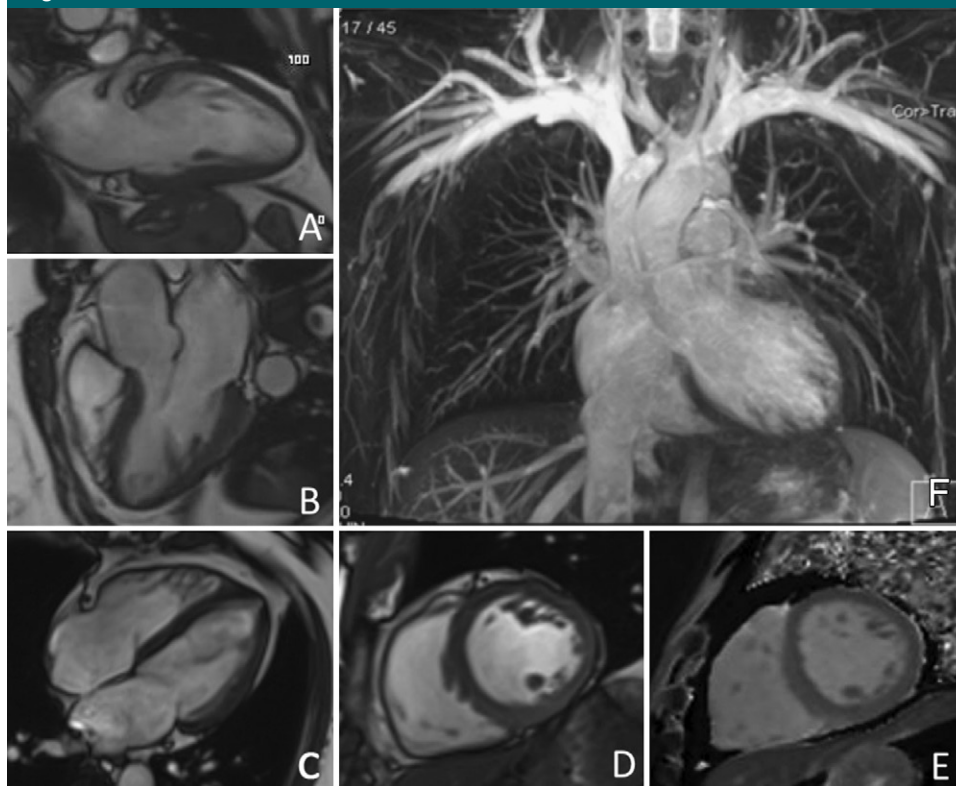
Examples of MR images acquired as part of the cardiovascular protocol: *A–C*, Long-axis MR images obtained with the cine steady-state free precession sequence. *D*, Short-axis MR image obtained with cine steady-state free precession sequence. *E*, MR image obtained with T1 mapping (modified look-locker inversion recovery). *F*, Native thoracic MR angiogram.
